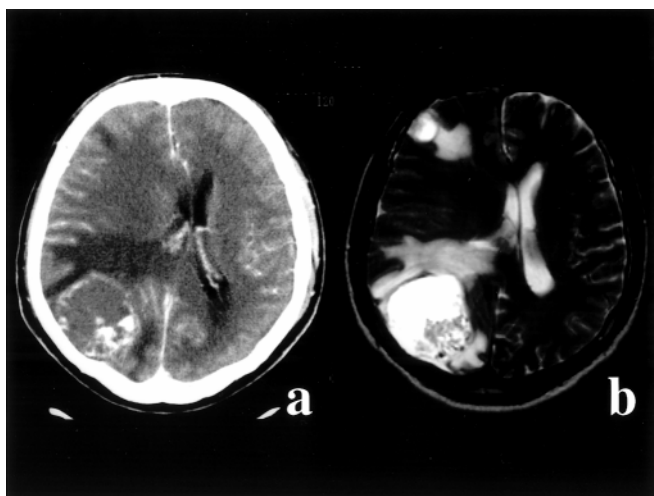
(a) Brain computed tomography (CT) revealing a ring-enhanced lesion with mass effect in the right parieto-occipital region. (b) T2-weighted magnetic resonance imaging (MRI) clearly demonstrates multiple cerebral metastases with hemorrhage.
